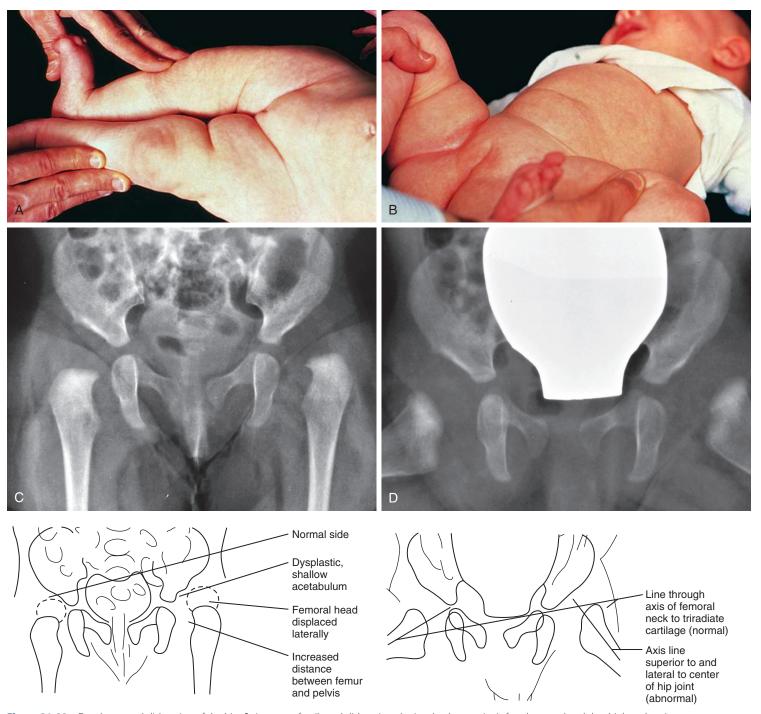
Developmental dislocation of the hip. A, In cases of unilateral dislocation, the involved extremity is foreshortened and the thigh and groin creases are asymmetric. B, Limited abduction of the involved hip is seen. This is a consistent finding in infants with a dislocated and irreducible hip. C, In this anteroposterior radiograph obtained in a 3-month-old child, the proximal left femur is displaced upward and laterally, and the acetabulum is shallow. The femoral head is not visible on the radiograph because of the delayed ossification associated with developmental hip dislocation. D, In the frog-leg view, the long axis of the affected left femur is directed toward a point superior and lateral to the triradiate cartilage, in contrast with that of the right, which points directly toward this structure.
